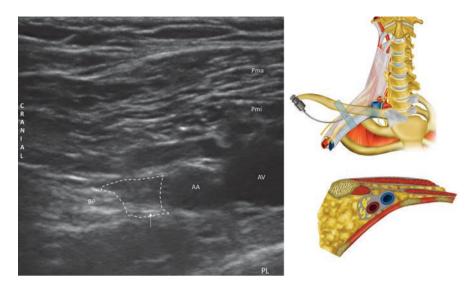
Ultrasound of infraclavicular area and hydrodissection, titrated with D5W opening space and confirming positioning of needle tip between brachial plexus and axillary artery. BP – brachial plexus; AA – axillary artery; *AV* axillary vein; *Pma* pectoralis major; *Pmi* pectoralis minor; *PL* pleura; white arrow – needle; dashed line – D5W spread
